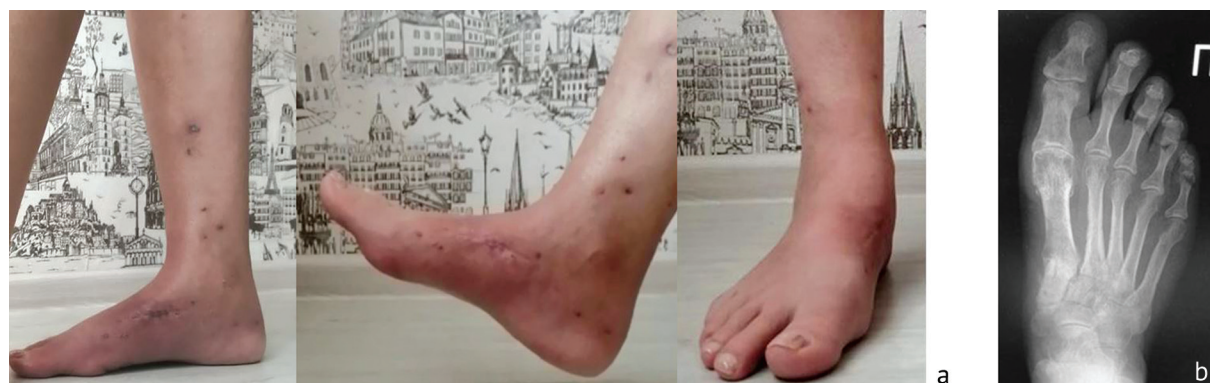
A year after surgery: a – photos; b – X-ray picture in AP view
